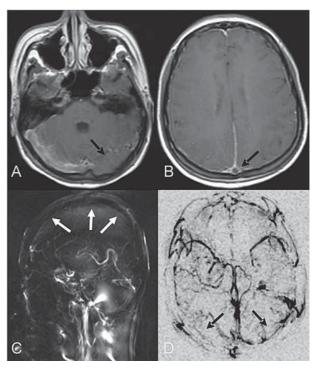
(A) Gadolinium-enhanced T1-weighted MRI revealed a lack of filling of the left transverse sinus (arrow). (B) A filling defect of the thrombosed SSS (arrow) gives the "empty delta sign". (C) and (D) MR venography demonstrated an inadequate or totally absent flow signal in the superior sagittal sinus (white arrow), and downstream in the sinus confluence and bilateral transverse/sigmoid sinuses (black arrow).
